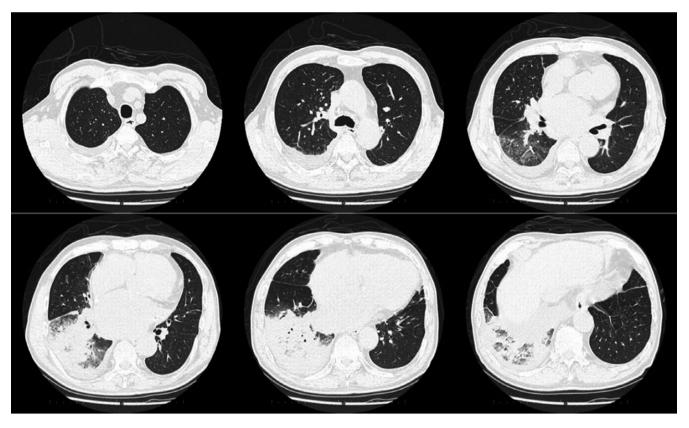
Computed tomography findings. The image shows the consolidation spanning the entire right lower lobe region
